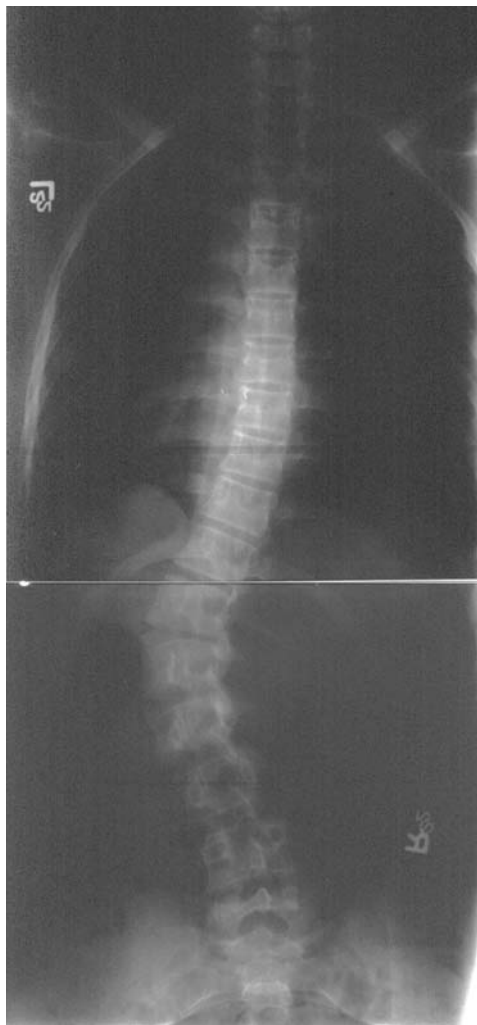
Posteroanterior radiograph of the spine in a patient with a thoracolumbar spinal curve. Left thoracolumbar curve, T10-L3 (most tilted vertebrae above apex of curve T10, most tilted vertebrae below apex of curve L3). The degree of curvature is 56.
